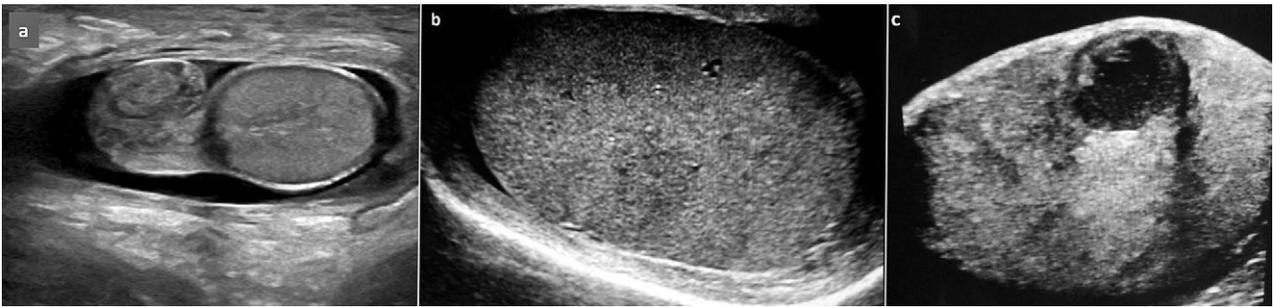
Ultrasonographic images of BEO cases: a) isolated epididymitis with enlarged, heterogeneous epididymis in a three-year-old patient; b) US image of a 24-year-old male demonstrates geographically, heterogeneous, hypoechoic areas related with orchitis; c) a thick-walled testicular abscess accompanied by a hypoechoic heterogeneous appearance of the neighboring testicular parenchyma in a 38-year-old case.
